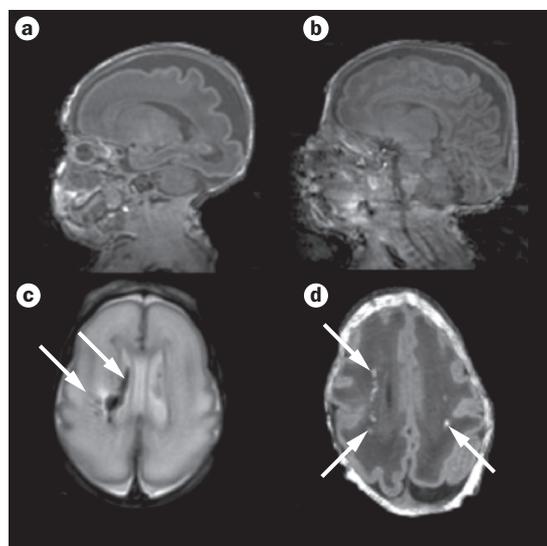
MRI scans of the brain in preterm newborn babies. a | MRI brain scan of a preterm newborn infant imaged at 26–27 weeks' postmenstrual age. b | MRI scan of the same infant taken 6 weeks after the scan in panel a. Note the substantial growth and increased complexity of the developing brain. c | MRI brain scan of a preterm infant imaged at 29 weeks' postmenstrual age, 1 week after birth showing hemorrhage in the brain tissue and ventricles (arrows). d | MRI brain scan of a preterm infant imaged at 30 weeks' postmenstrual age, 2 weeks after birth showing foci of white matter injury (arrows).
